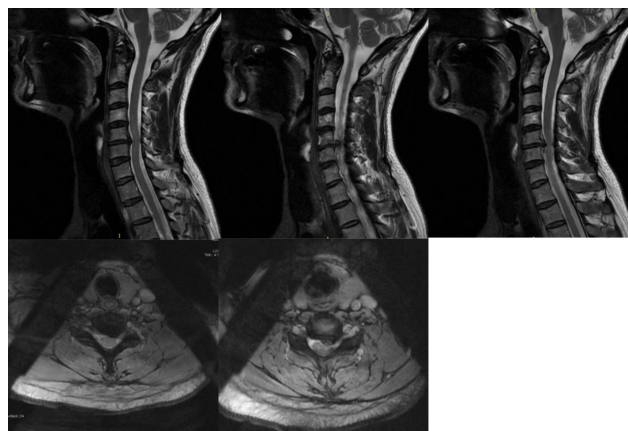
Preoperative T2-weighted sagittal-axial MRI revealing disc prolapse and spinal cord compression at the C5-C6 level.
